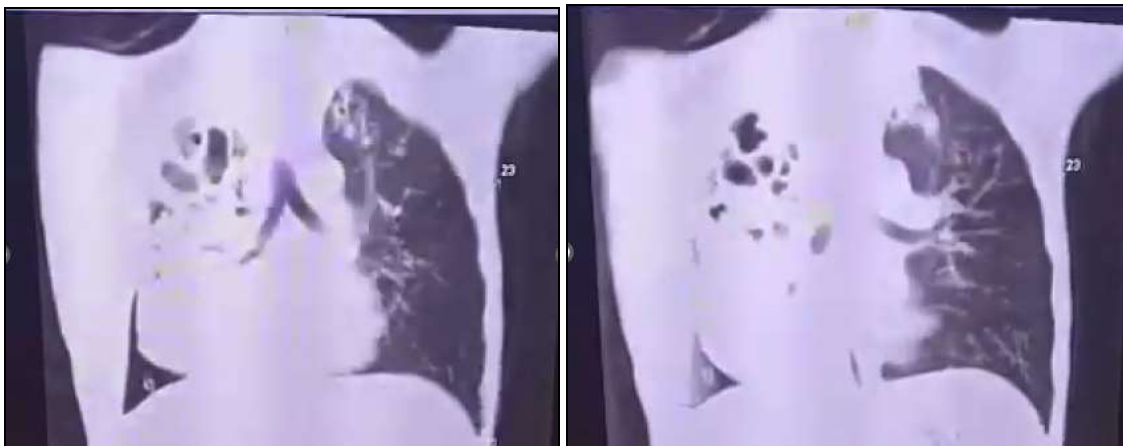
Thorax CT Scans showing atelectasis with bronchiectasis in the right lung
